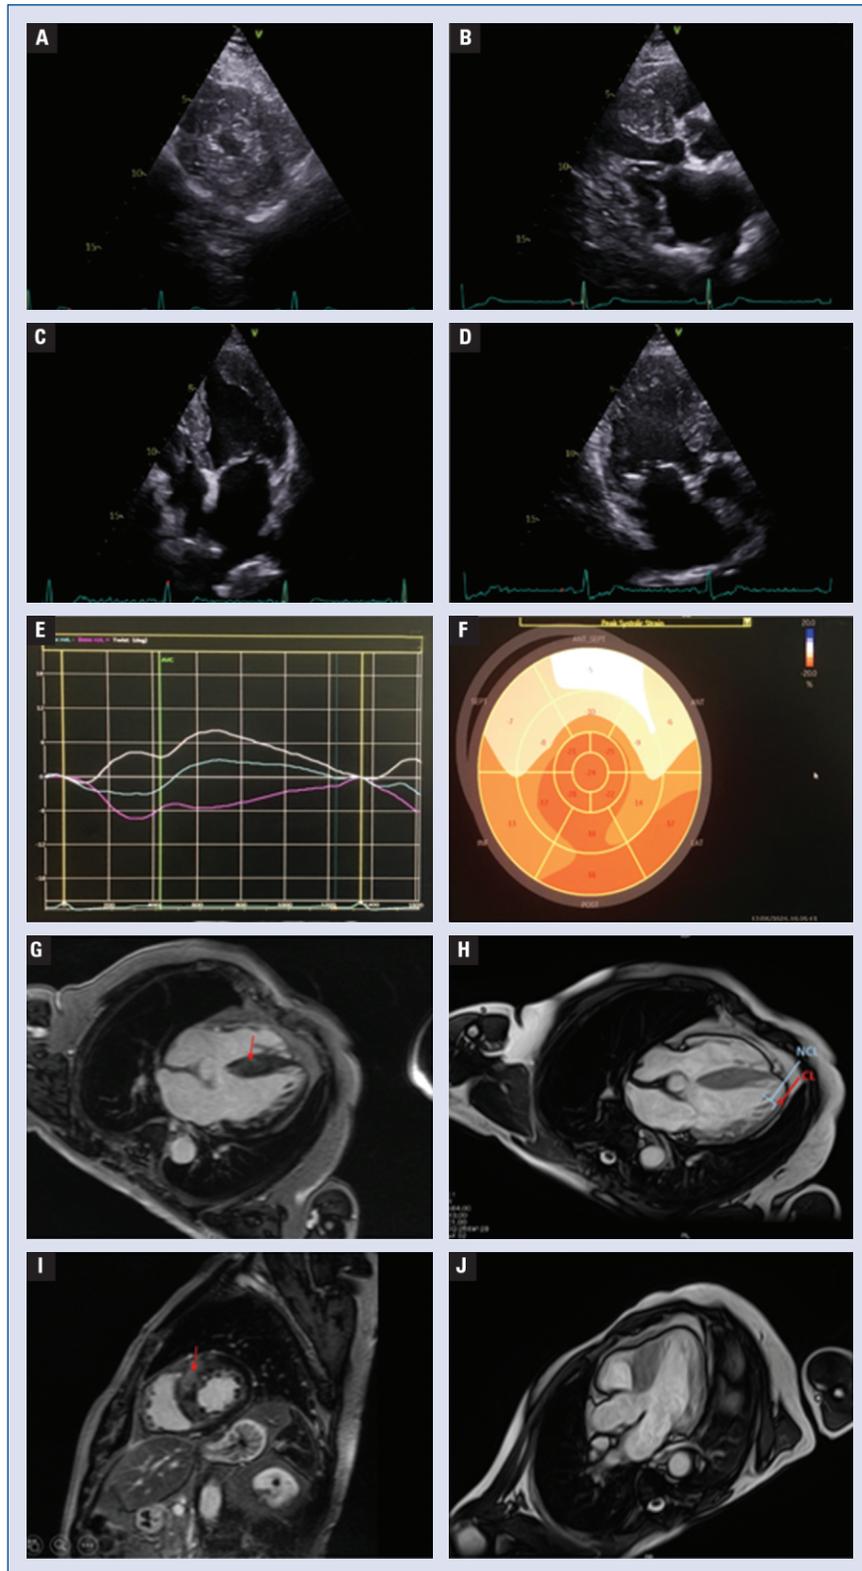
Transthoracic echocardiography (A, B, C, D) — two-dimensional: showing severe left ventricular hypertrophy and trabeculations in the left ventricle, visible only in the three chamber view (D). Circumferential (E) and longitudinal (F) strain analysis: showing reduced global longitudinal strain in the hypertrophied segments, and reduced twist provoked by the base and apex rotating in the same direction. Late gadolinium enhancement (LGE) cardiac magnetic resonance (CMR) sequences (G, I): marked asymmetric septal hypertrophy associated with diffuse intramural non-ischemic LGE (fibrosis) within the hypertrophied segments (arrows), translating the diagnosis of hypertrophic cardiomyopathy. CINE CMR sequences (H, J), demonstrating the non-compacted and compacted layers of the myocardium with a trabecular/thin layer ratio of 2.3 at end-diastole in medium-apical lateral segments, a feature of left ventricle non-compaction; NCL — non-compact layer; CL — compact layer.
